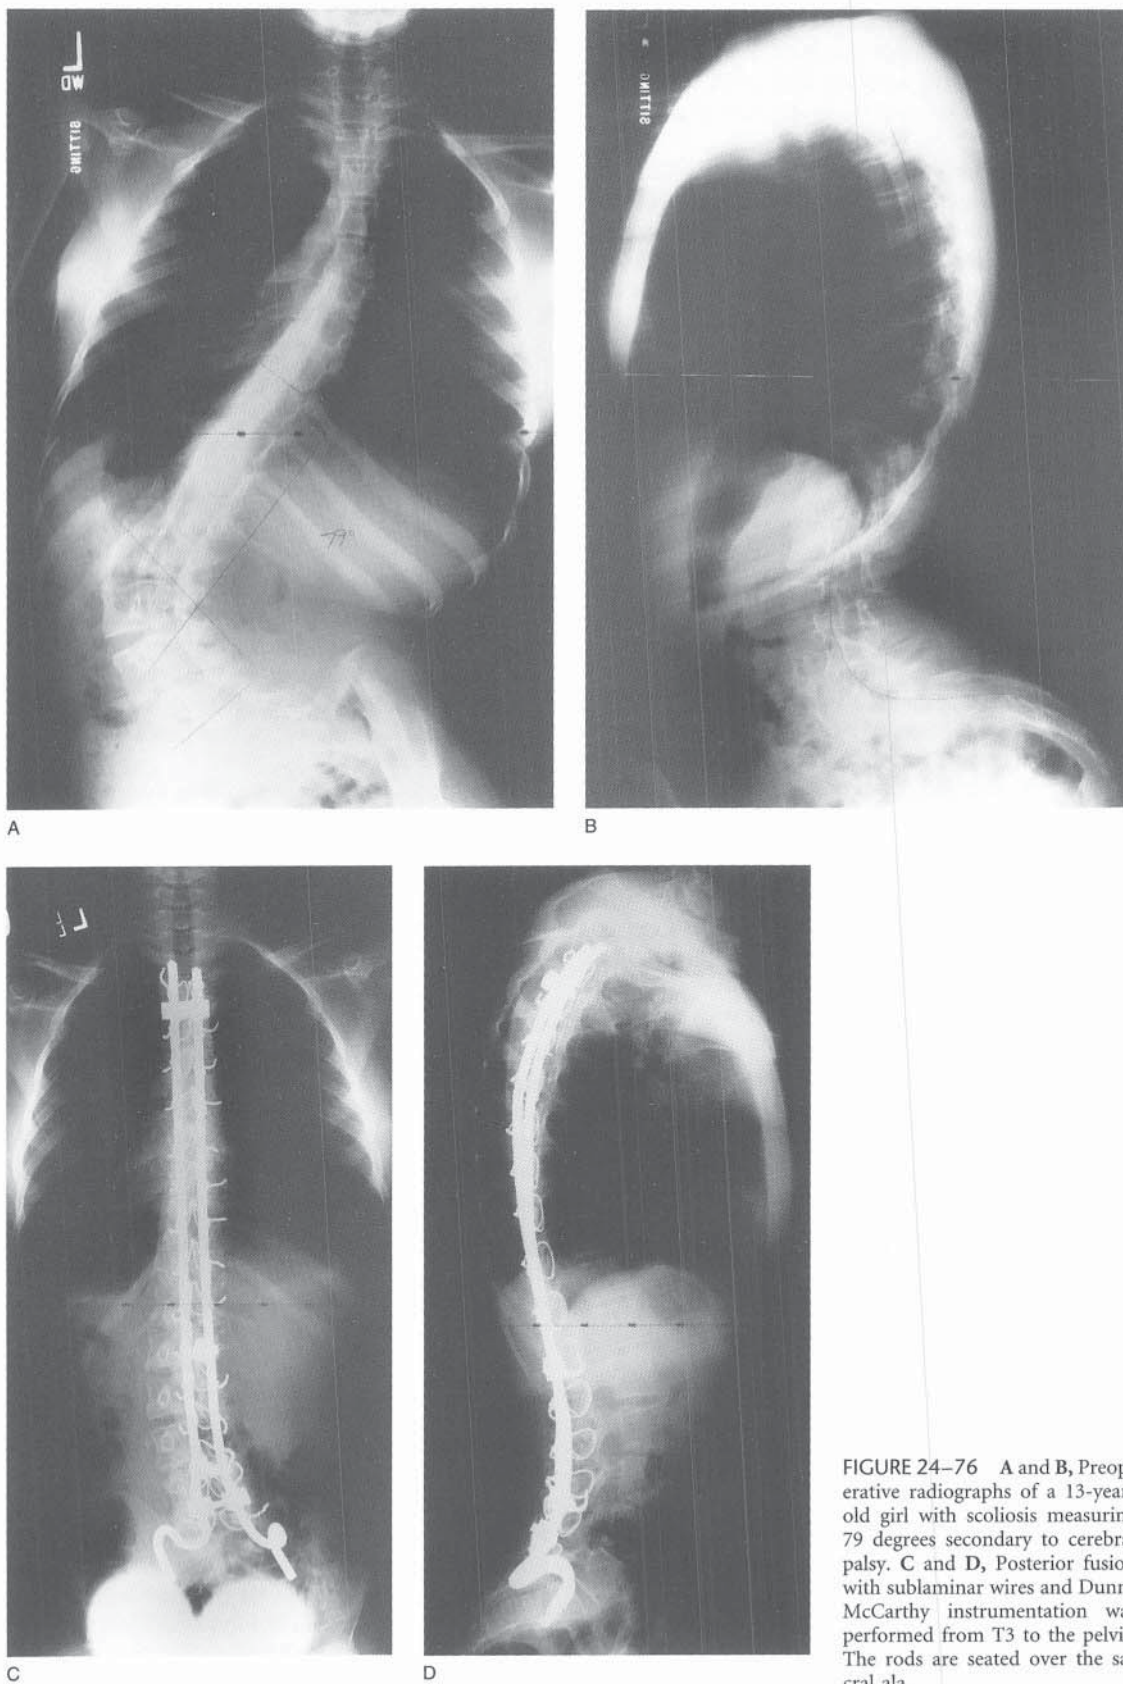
A and B, Preoperative radiographs of a 13-year-old girl with scoliosis measuring 79 degrees secondary to cerebral palsy. C and D, Posterior fusion with sublaminar wires and Dunn-McCarthy instrumentation was performed from T3 to the pelvis. The rods are seated over the sacral ala.
